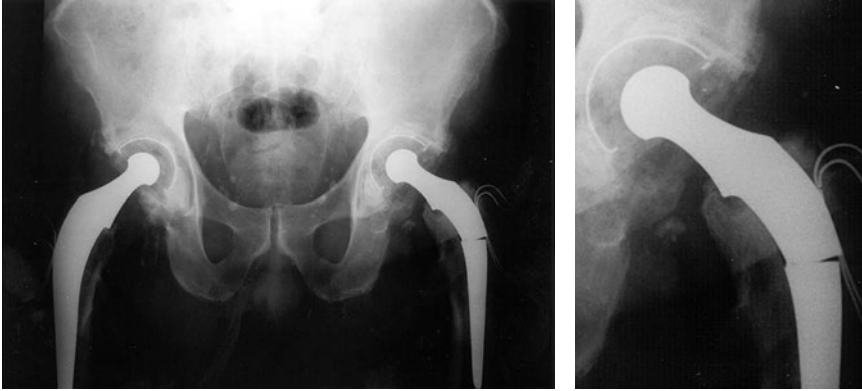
Radiograph of a bilateral total hip replacement. The left prosthesis was broken after 27 years of successful functioning. *Right*: detail of cup, head and broken part
